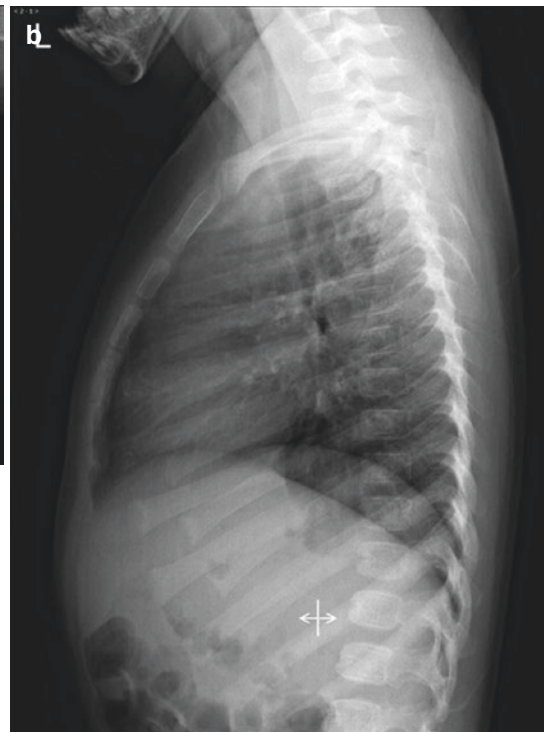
Pulmonary valve stenosis in a 16-month-old boy with heart murmur detected 3 months after birth. Chest radiographs (a and b: PA and lateral views) show
